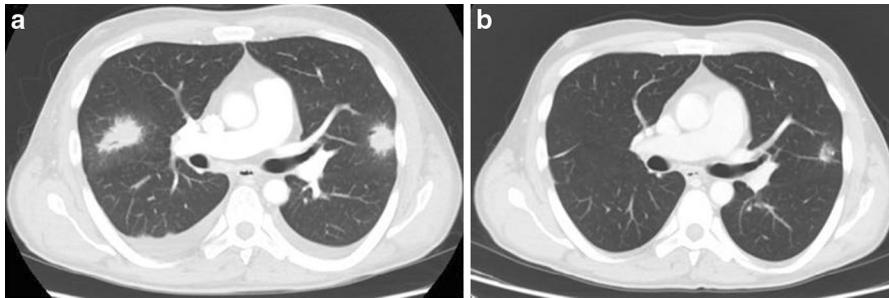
a CT scan of thorax: right and left upper lobe nodules with ground-glass opacity associated. b Reduction of right and left lesions after liposomal amphotericin B plus voriconazole
